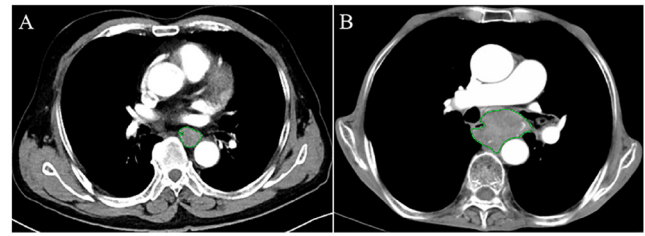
Manual delineation along the edge of thickened esophageal wall on a contrast-enhanced CT scan. (A) Region of interest of resectable esophageal squamous cell carcinoma in the middle thoracic portion in a male aged 64 year. (B) Region of interest of unresectable esophageal carcinoma with the invasion of the left main bronchus in the middle thoracic portion in a male aged 74 years.
